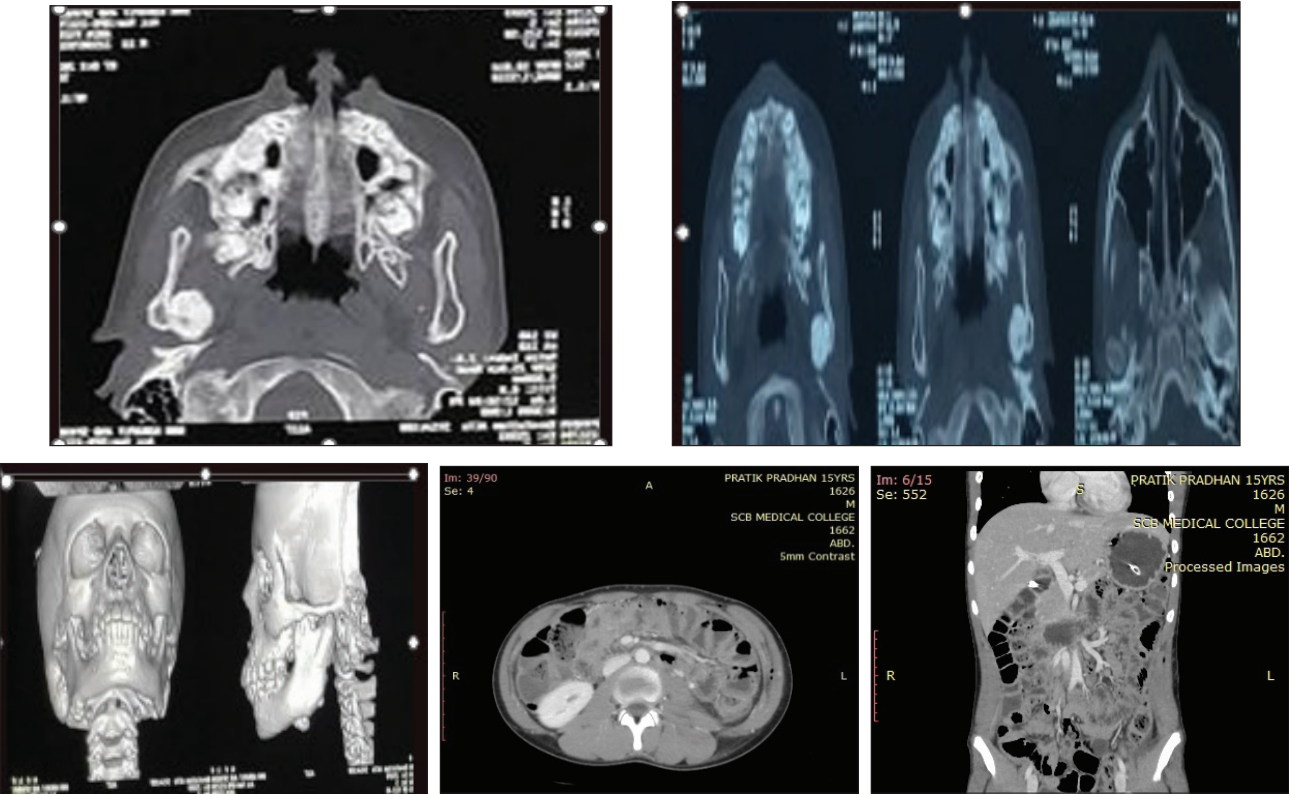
(a) Axial CECT image showing a well-defined hyperdense osseous lesion involving the left mandibular angle and adjacent paranasal sinus region, with no soft-tissue component. (b) Serial section of axial the images demonstrate well-defined, homogeneously radiopaque osseous masses involving the maxilla mandible and adjacent paranasal sinus regions. The lesions are smoothly marginated, causing expansion and partial sinus obliteration, but without evidence of cortical destruction or soft tissue invasion. (c) CECT face. (d) Axial contrast CT abdomen. (e) coronal contrast CT abdomen.
